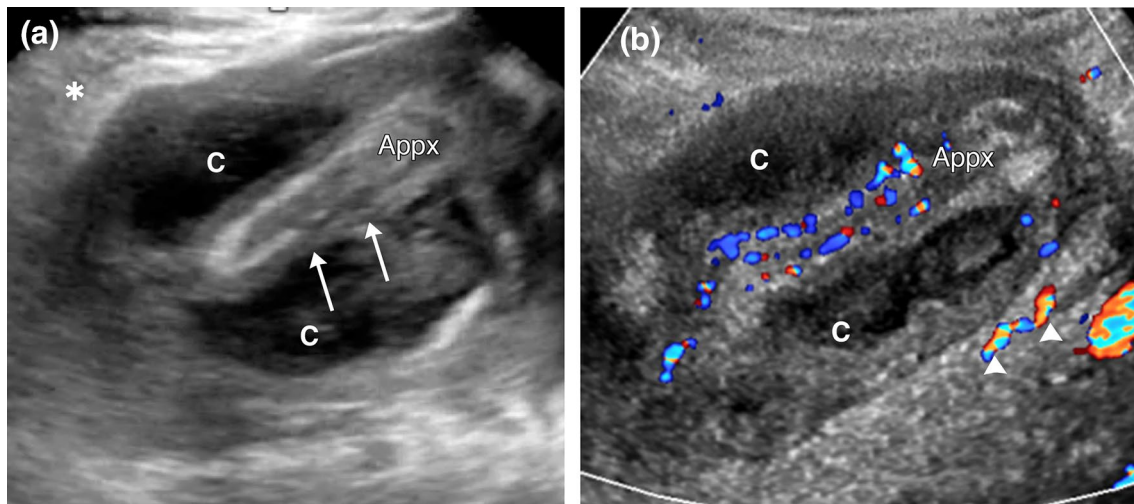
Acute appendicitis complicated by perforation and abscess formation in a 7-year-old male who presented with 2 weeks of right lower quadrant abdominal pain. a Gray scale and b color Doppler images in longitudinal plane obtained in the right lower quadrant show collapsed inflamed appendix (Appx) with thick hyperemic
